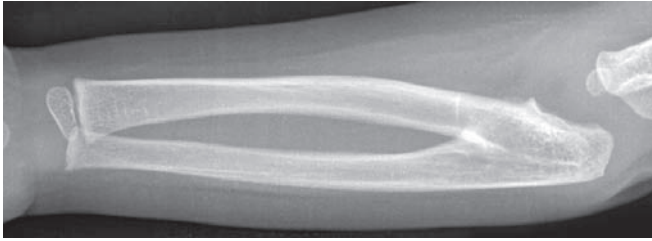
Radiograph of a child's elbow showing congenital synostosis of the radius and ulna
